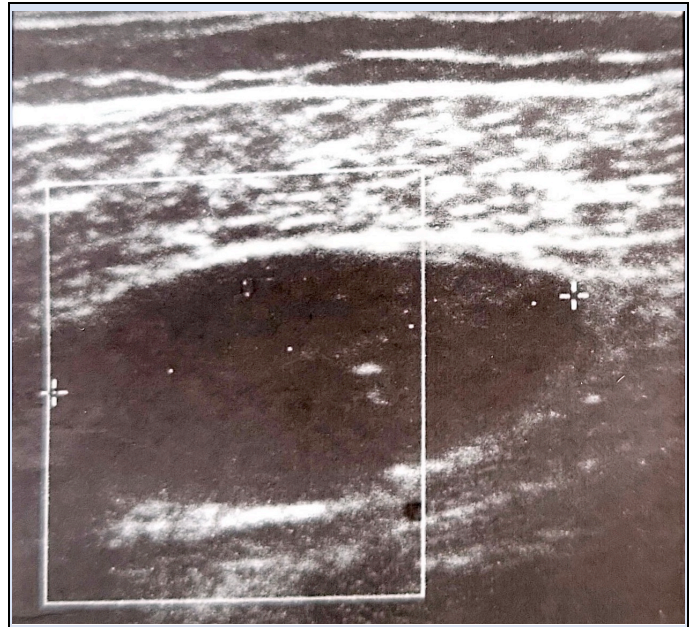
Lower leg soft tissue ultrasound demonstrating well circumscribed oval lesion in the region of the middle third of the calf muscles
